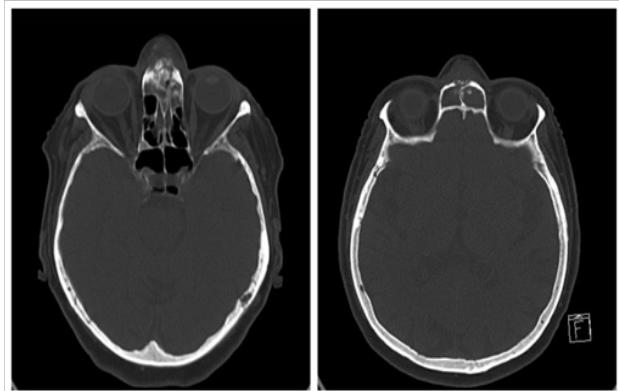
(left): Axial CT image of the patient showing engagement of the nasal meat uses.
